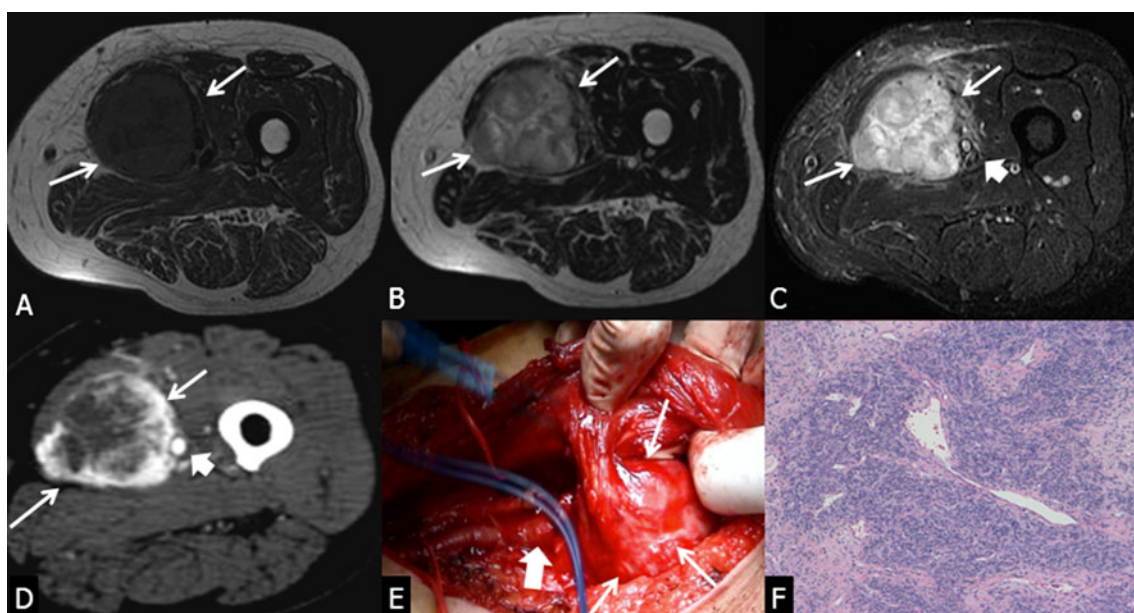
IMT of the thigh. a MR axial SE T1-weighted image shows space-occupying lesion (arrows) at the level of antero-medial compartment of thigh with close relationship with blood vessels. MR axial FSE T2-weighted images without (b) and with (c) fat suppression on the same plane show the intermediate-low signal intensity of the mass (long arrows); note compressed and displaced
